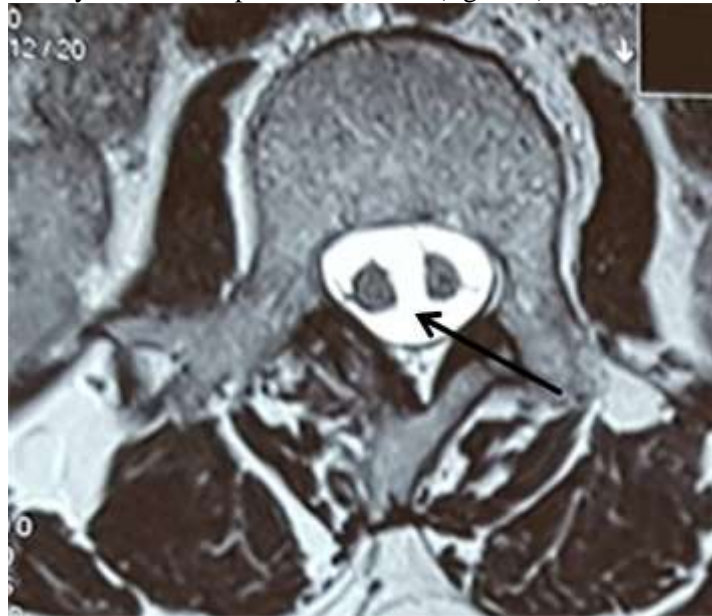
Axial MRI showing two hemi cords housed in a single dural tube separated by a median septum (black arrow)
